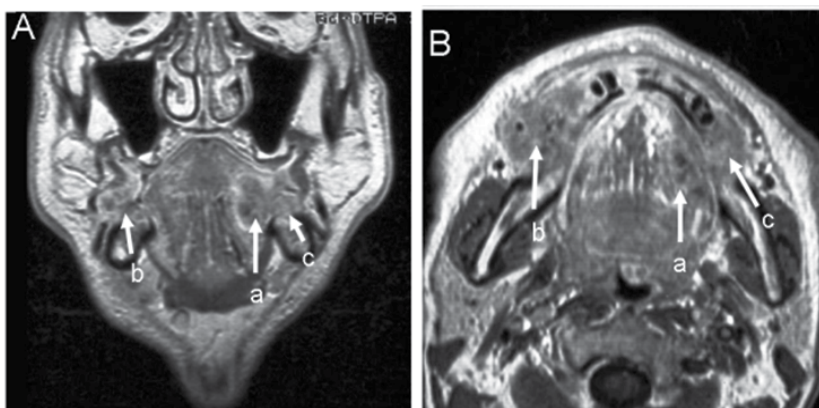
T1- weighted coronal (A) and axial (B) magnetic resonance images showing ill-defined, hypo-intense masses surrounded by a Gd-enhanced outer margin in left side of the tongue (a), right molar region (b), and the left molar region (c).
